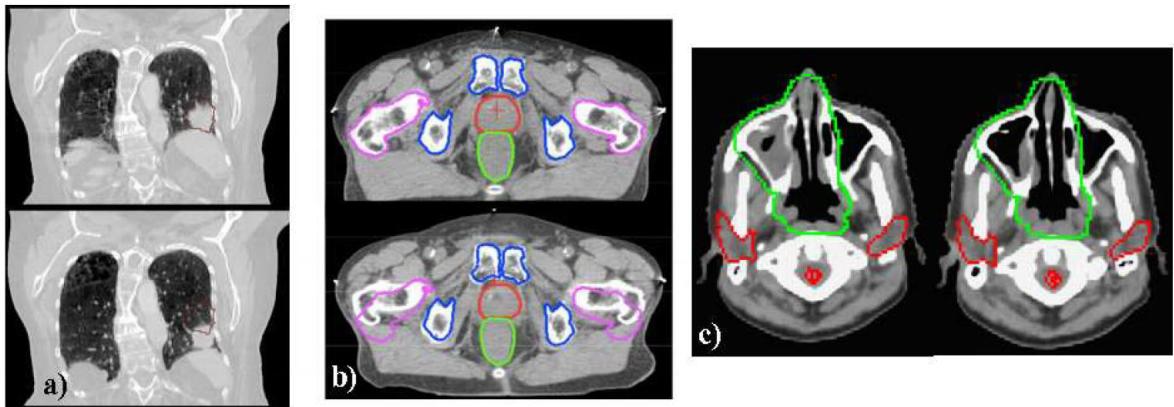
Examples of the three major motion categories. On the left side (a) a lung tumor is displayed, which moves due to the respiration of the patient (intrafractional motion). Interfractional position changes are exemplary shown in the middle (b), where two CT scans of a prostate patient are compared. Density variations between two CT scans are shown in (c). Figure taken from [Engelsman and Bert, 2011]
